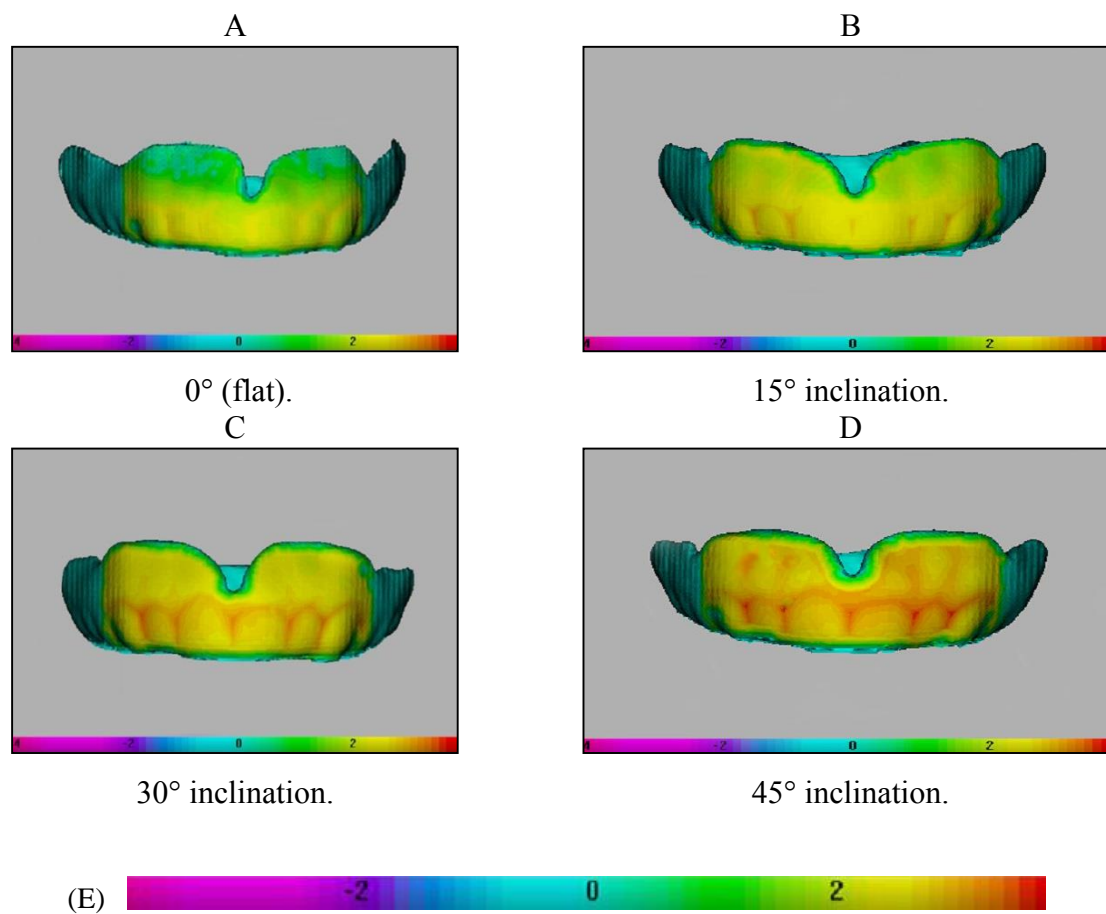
CT scan of the finished mouthguard formed flat on the forming platform (A), positioned at angles of 15° (B), 30° (C), and 45° (D). (E) Shows an enlarged thickness/colour key, 0 mm to ± 4 mm.
